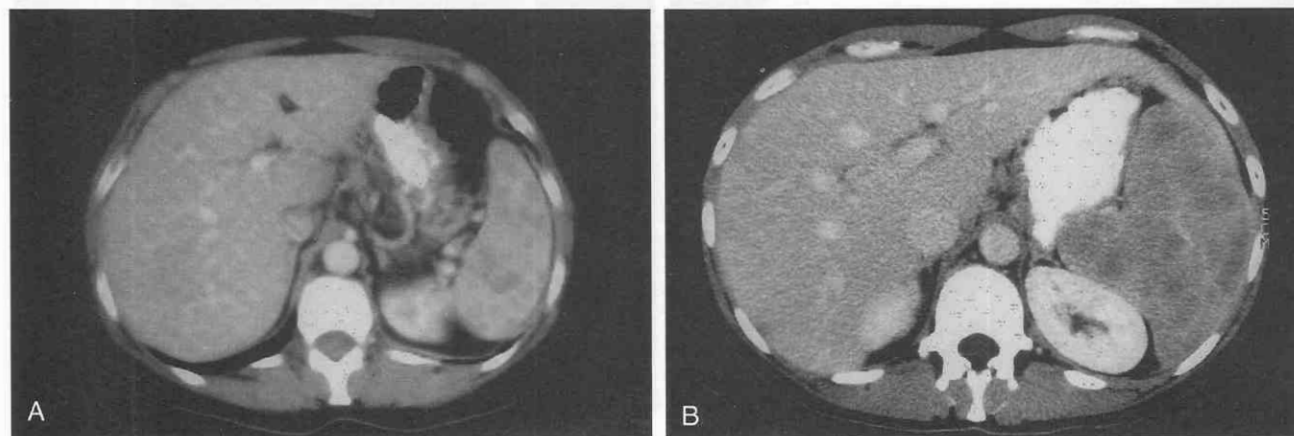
CT scans showing sarcoidosis of the spleen. A, Multiple small, nonenhancing foci of sarcoidosis in the spleen. The liver is not involved. B, Diffuse involvement of the spleen by sarcoid. The lesions are nonenhancing, and splenomegaly is present.
